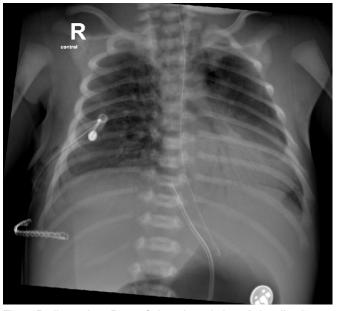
Radiography – Day 5: Subtotal resolution of air collections after surgical drain, under HFOV.
